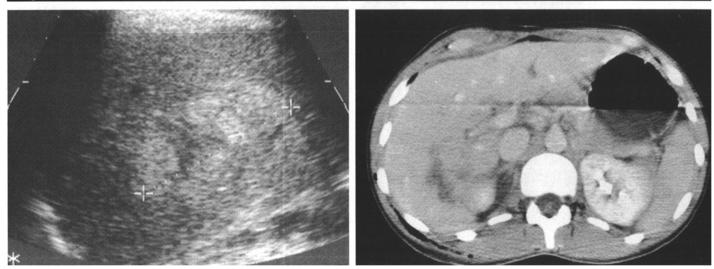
24-year-old woman injured in a motor vehicle accident. Left, transverse US scan of the right lobe of the liver shows an ill-defined intraparenchymal lesion with hyper- and hypoechoic parts, characteristic of a hematoma of the right lobe of the liver. Right, enhanced abdominal CT, performed approximately 30 minutes later, confirms this hematoma as a hypodense lesion of the right lobe of the liver.
